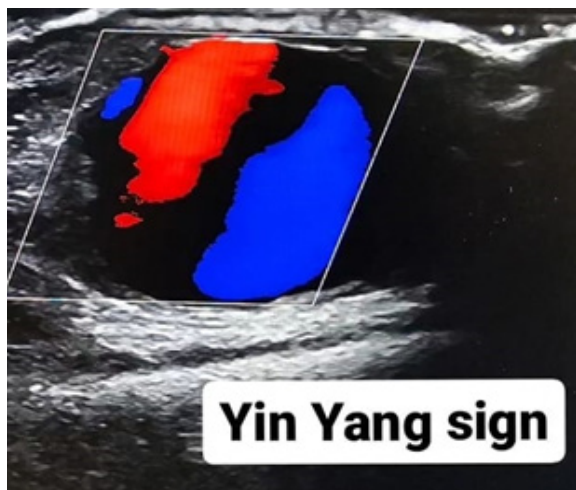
The Classic “Yin-Yang” Sign On Doppler Ultrasound, Indicates Pseudoaneurysm
